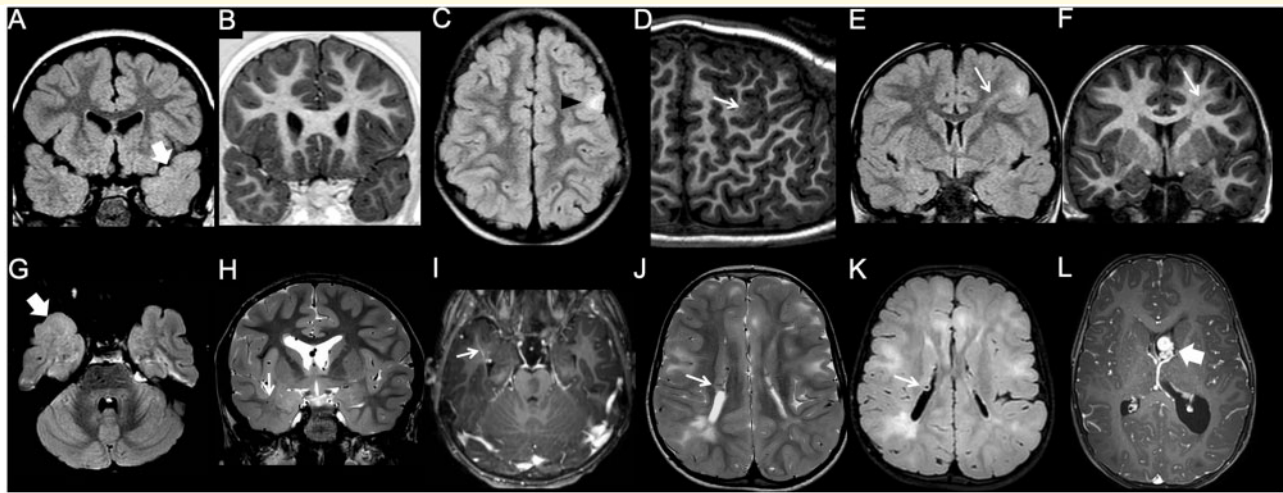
Imaging characteristics of focal cortical dysplasia. (A and B) Type I FCD. The left temporal pole is slightly smaller than the contralateral, and there is a blurred grey-white matter junction, with abnormal myelination compared to the contralateral side, best seen on the FLAIR image (arrow). (C and D) Type IIa FCD. There is focal, FLAIR-hyperintense cortico-subcortical lesion in the left frontal lobe (arrowhead). Curvilinear 3D T₁ reformat shows corresponding focal blurring of the grey-white matter junction (arrow). (E and F) Type IIb FCD. Focal cortico-subcortical area of hyperintensity in FLAIR, and hypointensity in T₁ is associated with typical transmantle sign (arrow). (G–I) Type III FCD. Slightly hypoplastic right temporal pole is associated with a blurred grey-white matter junction, better appreciated on the FLAIR image (thick arrow). Notice associated draining vein of a developmental venous anomaly (thin arrow). (J–L) Tuberous sclerosis complex. Typical, diffuse cortical tubers and white matter lesions are associated with subependymal nodules (thin arrows) and a subependymal giant cell astrocytoma arising at the left foramen of Monro (thick arrow).
